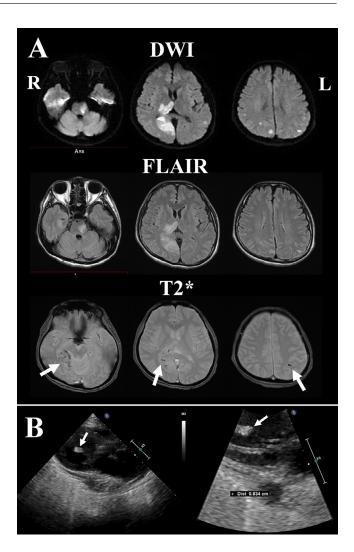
(A) Magnetic resonance imaging on admission. Diffusion-weighted images demonstrating several lesions in both hemispheres, denoting multiple areas of acute ischemia. The main lesions are in the left pons, right occipital lobe, thalamus, and posterior limb of the internal capsule. These lesions are shown as high signals on FLAIR, suggesting cerebral infarctions. Microbleeds in the fresh infarctions are identifiable on T2\* images as spotty low signal lesions (white arrows). (B) Echo cardiography on admission. Echocardiography showing a 0.83-cm mass in the left ventricle that is fluttering synchronously with the heartbeat.
